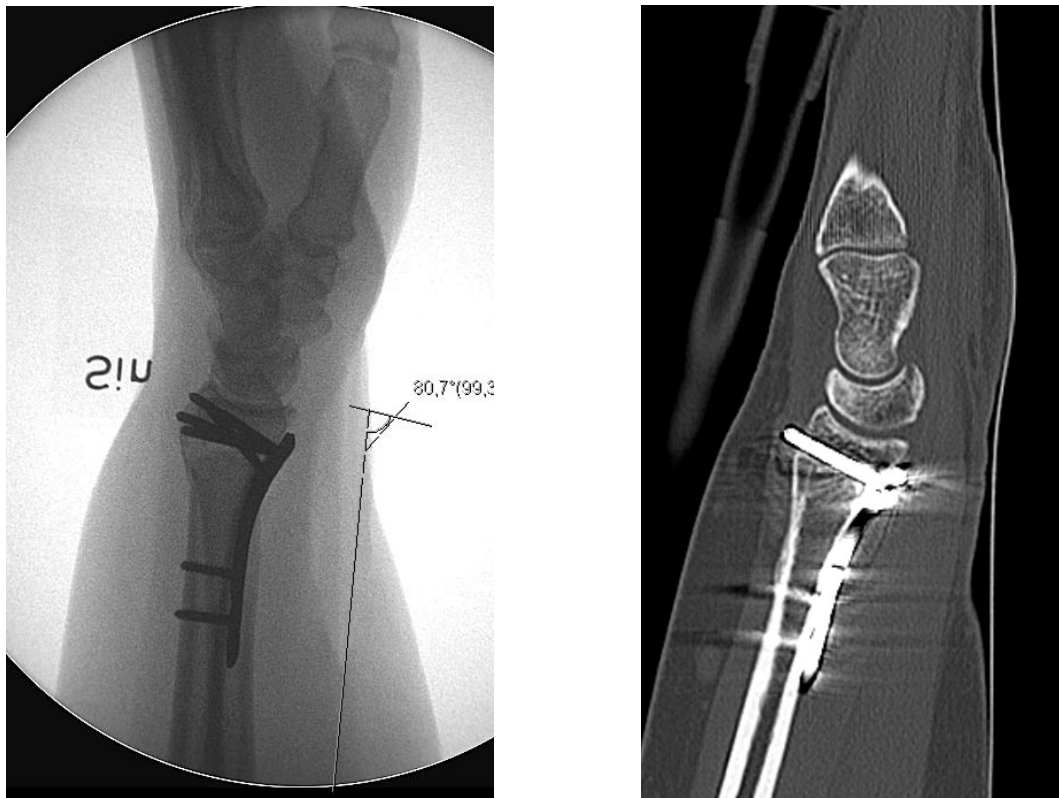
Computed tomography revealing inadequate screw length.
